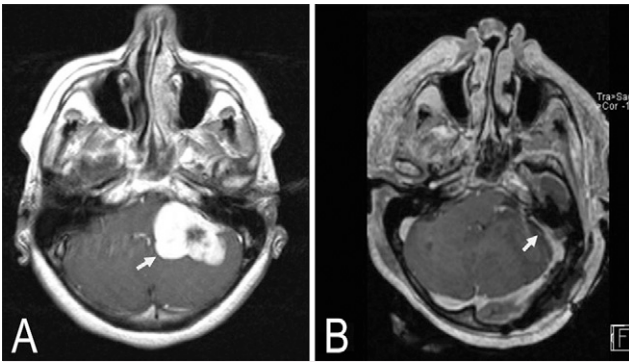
Axial view MRI T1 with contrast. A: Preoperative image showing heterogeneously enhancing mass in the left perimesencephalic/CPA cistern. B: Postoperative image showing gross total resection of the tumor through extended retrosigmoid craniotomy.
